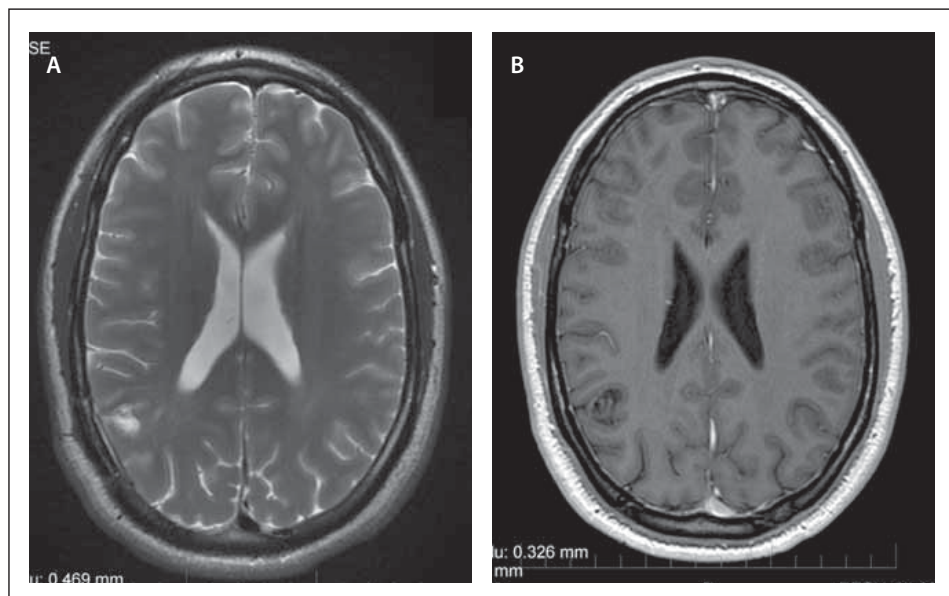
MRI findings of the polymorphous low-grade neuroepithelial tumor of the young. (A) T2-weighted axial image with a hyperintensity in the right parietal lobe and no collateral edema.
